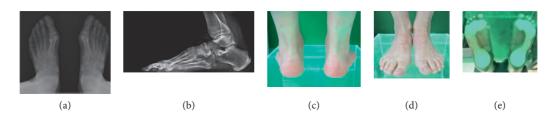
(a-e) Results of imaging tests (X-ray) and podoscopic tests: patient no. 1. (a). Dorsal-plantar foot X-ray: hallux valgus, subluxation of sesamoid bones, overloaded cuneometatarsal joint, and osteophytes in the area of navicular bone.(b) Lateral X-ray: Achilles tendon enthesopathy and numerous calcifications. (c) Posterior picture: ankle joint and hindfoot evaluation. (d) Anterior picture of the feet: assessment of toe positioning and deformation. (e) Plantar photo on the podoscope: evaluation of plantar part of the foot and height measurement of the longitudinal arch.
